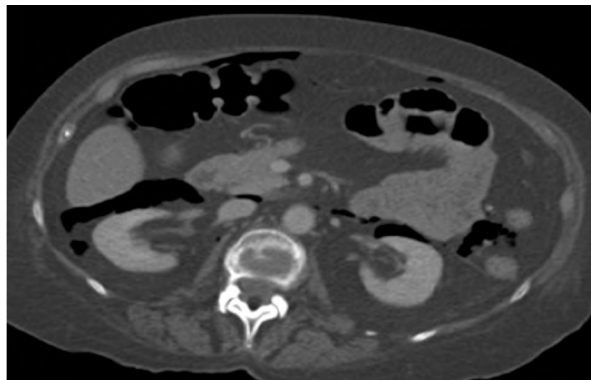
Axial CT demonstrating free intraperitoneal gas indicative of perforation.
